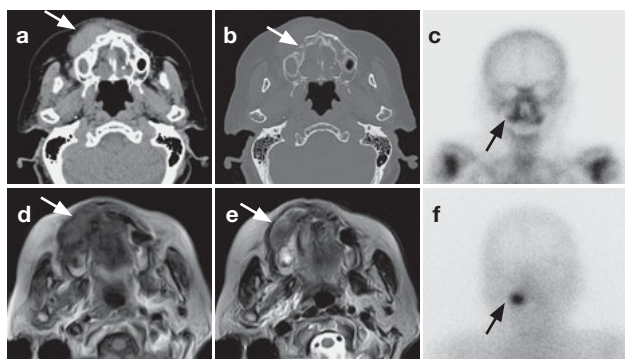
Malignant melanoma of the right side of the maxilla in an 81-year-old female. Axial soft tissue algorithm CT (a) and bone tissue algorithm CT (b) show a mass lesion with the destruction of buccal cortex in the right maxilla (arrow). Bone scintigraphy shows increased uptake (arrow) (c). On MRI, axial T1-weighted image (T1WI) revealed homogeneous, low-signal intensity (arrow) (d). T2-weighted image (T2WI) revealed heterogeneous, low-signal intensity (arrow) (e). ^{67}Ga scintigraphy shows increased uptake in the maxilla (arrow) (f).
